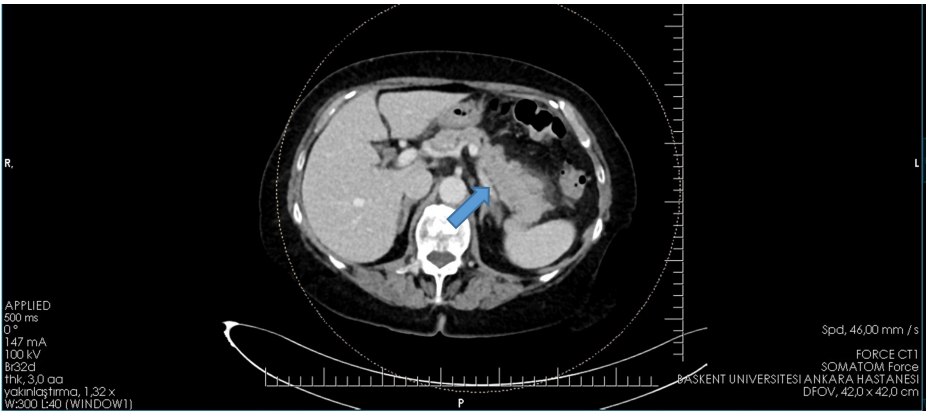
Abdomen computed tomography examination, an appearance suggestive of acute focal pancreatitis in the tail of the pancreas and surrounding edema.
